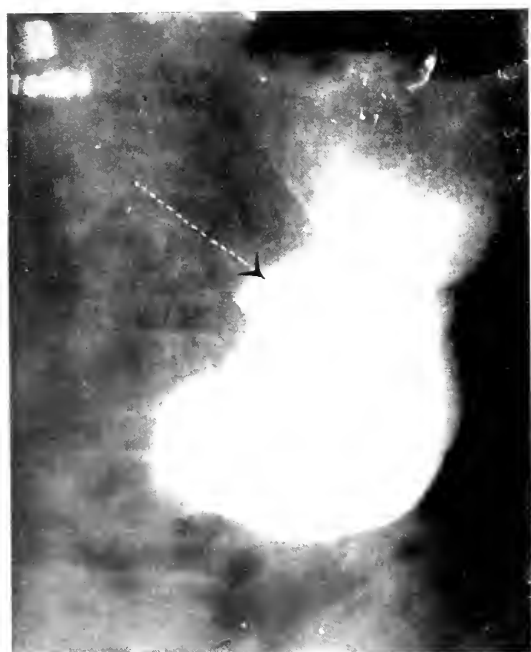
CASE 110521. Roentgenogram. Niche-type of ulcer, malignant. Arrow points to niche.
